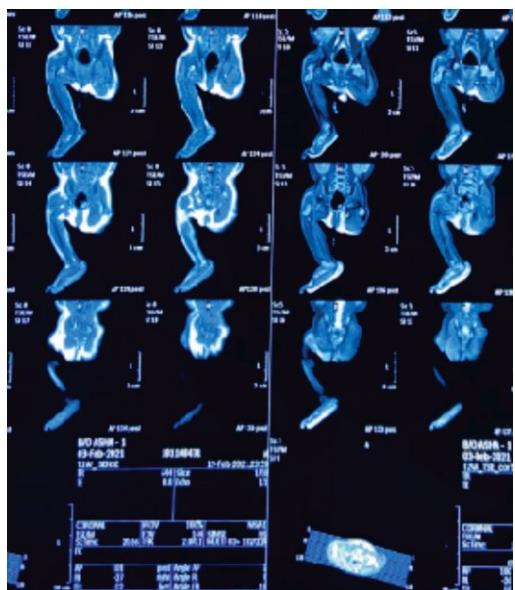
MRI pelvis and bilateral lower limbs
